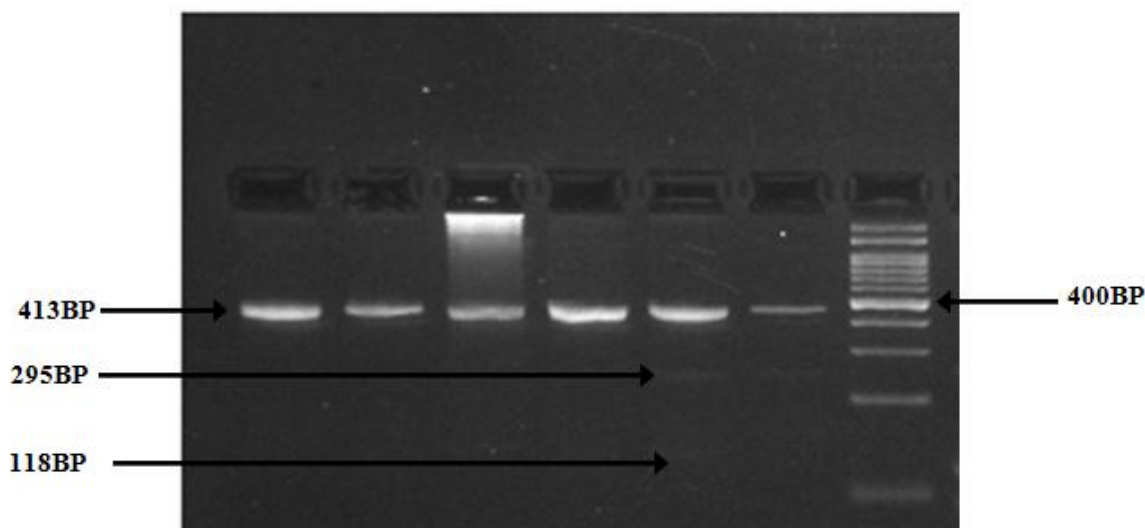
4% Agarose gel analysis of CYP2E1 (1091) polymorphism. Lane 7 100 bp Ladder, Lane1, 2,3,4 TT genotype 413 bp, Line 5,6 CT genotype 413, 118, 295 bp.
